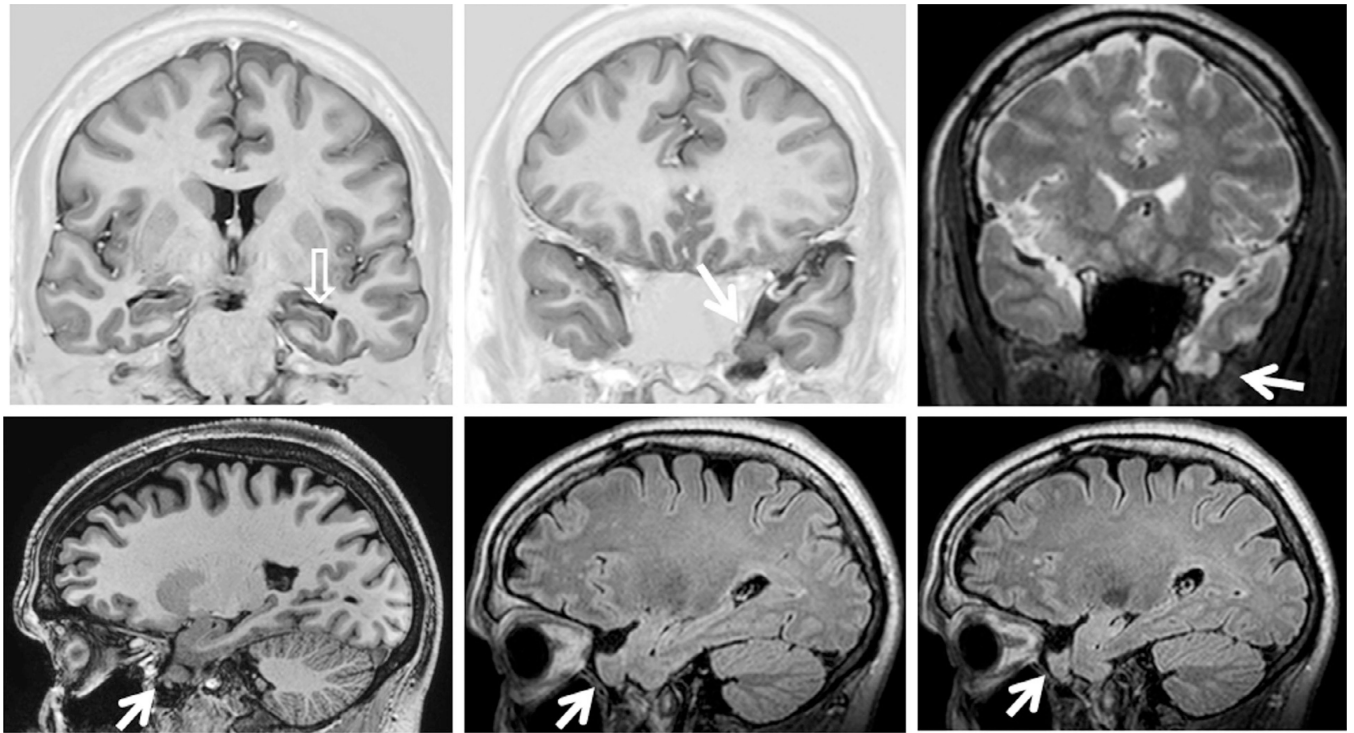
Coronal T1-weighted inversion recovery and T2-weighted images (top) and sagittal T1-weighted and fluid-attenuated inversion recovery images showing a small left anterior temporal encephalocele (arrows) and a left hippocampus with an abnormal shape and loss of internal structure (open arrow), in a patient with left temporal-lobe epilepsy.
